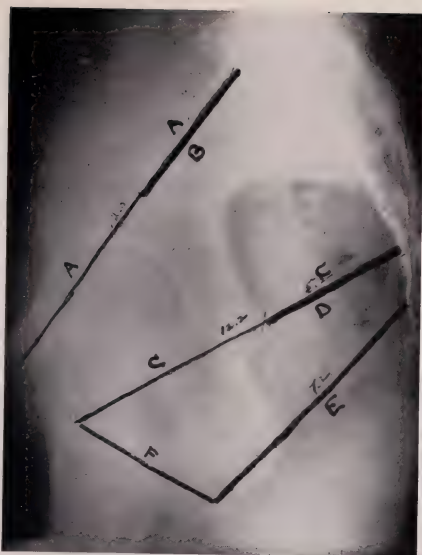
Lateral roentgenogram. Diameters as shown in figure 2 (correction scale not shown)
